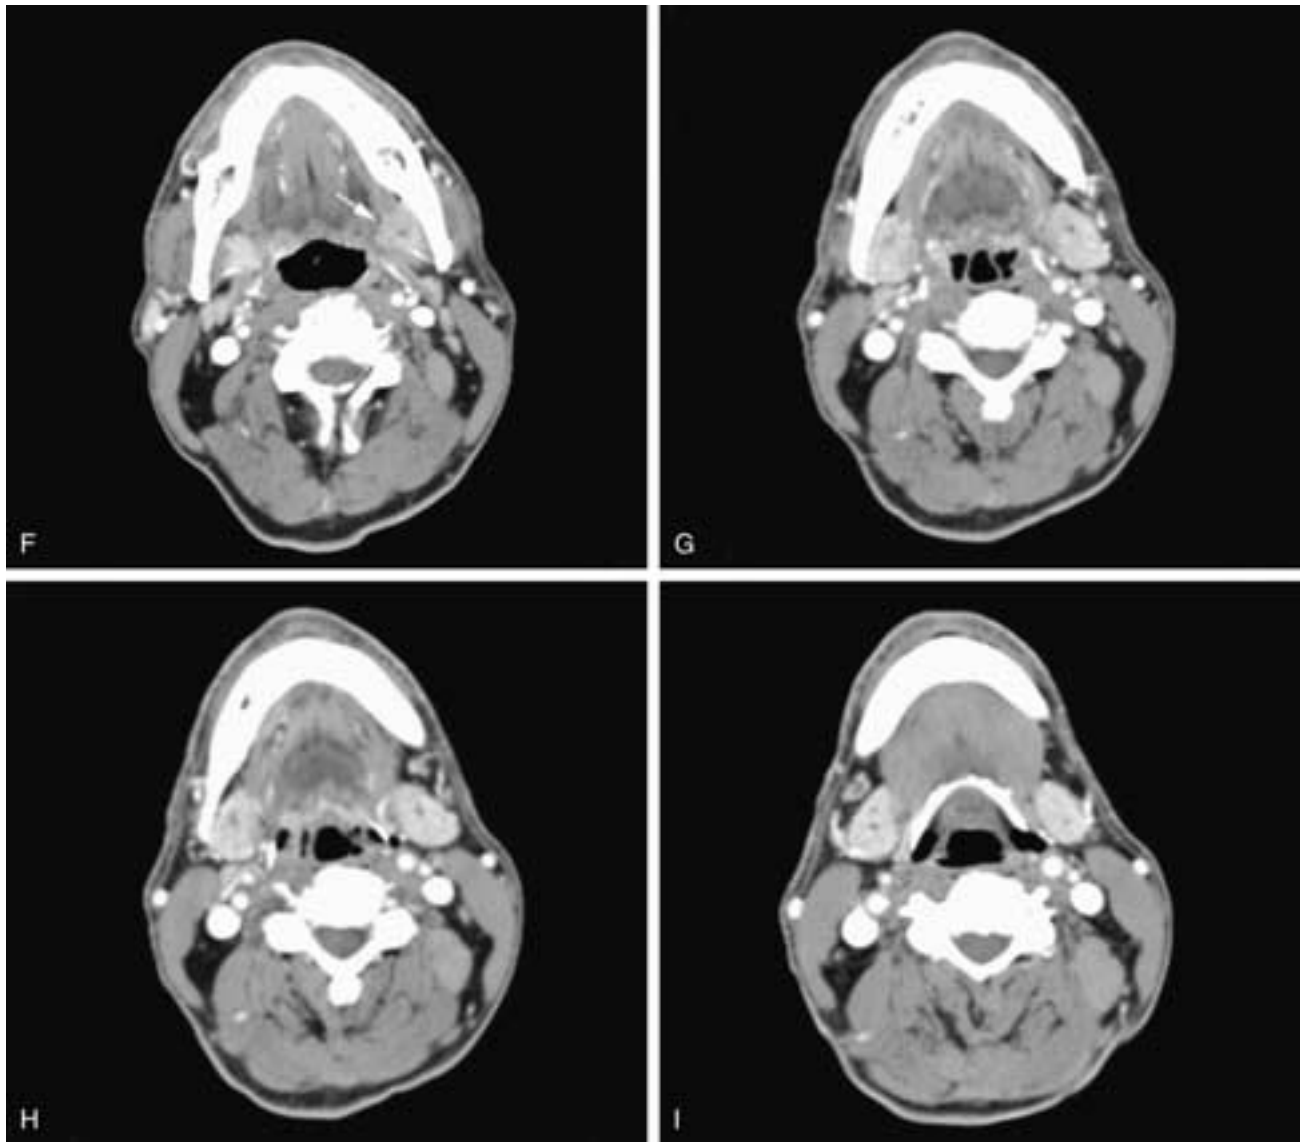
Continued.* Serial contrast-enhanced CT scans from cranial (F) to caudal (I) show the normal symmetric enhancement of the submandibular glands. In F, the hilum of the gland is seen above the posterior edge of the mylohyoid muscle (*arrow*). In G to I, there is minimal symmetric visualization of the intraglandular ducts. This is a normal imaging appearance.
